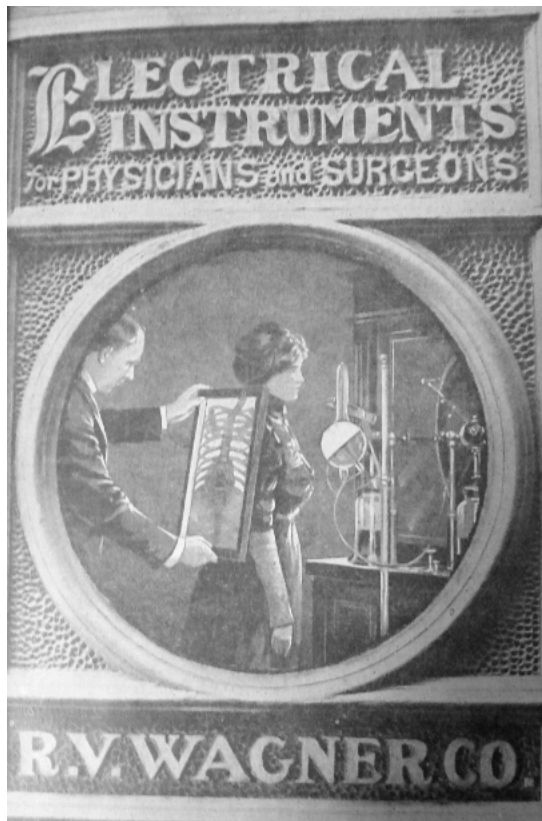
Women were commonly featured at the object of the x-rays' gaze⁴⁷³
